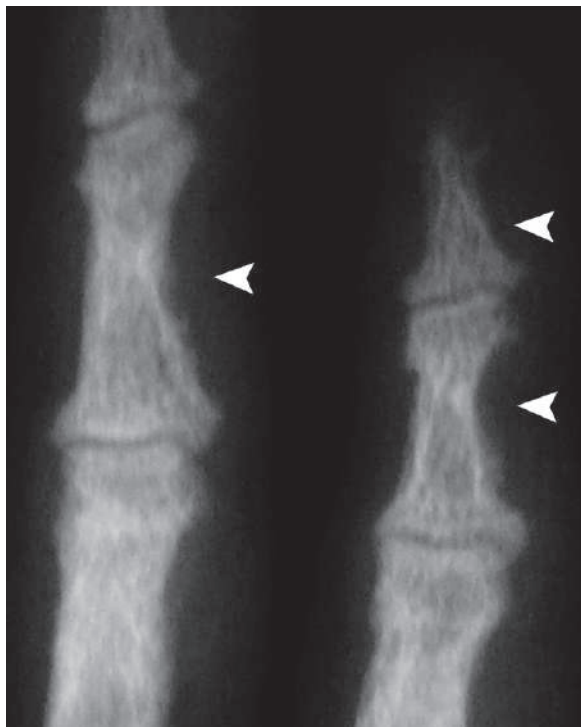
A plain radiograph of the fingers shows radial side subperiosteal resorption of the middle and distal phalanges (*arrowheads*), a specific sign of prolonged hyperparathyroidism
